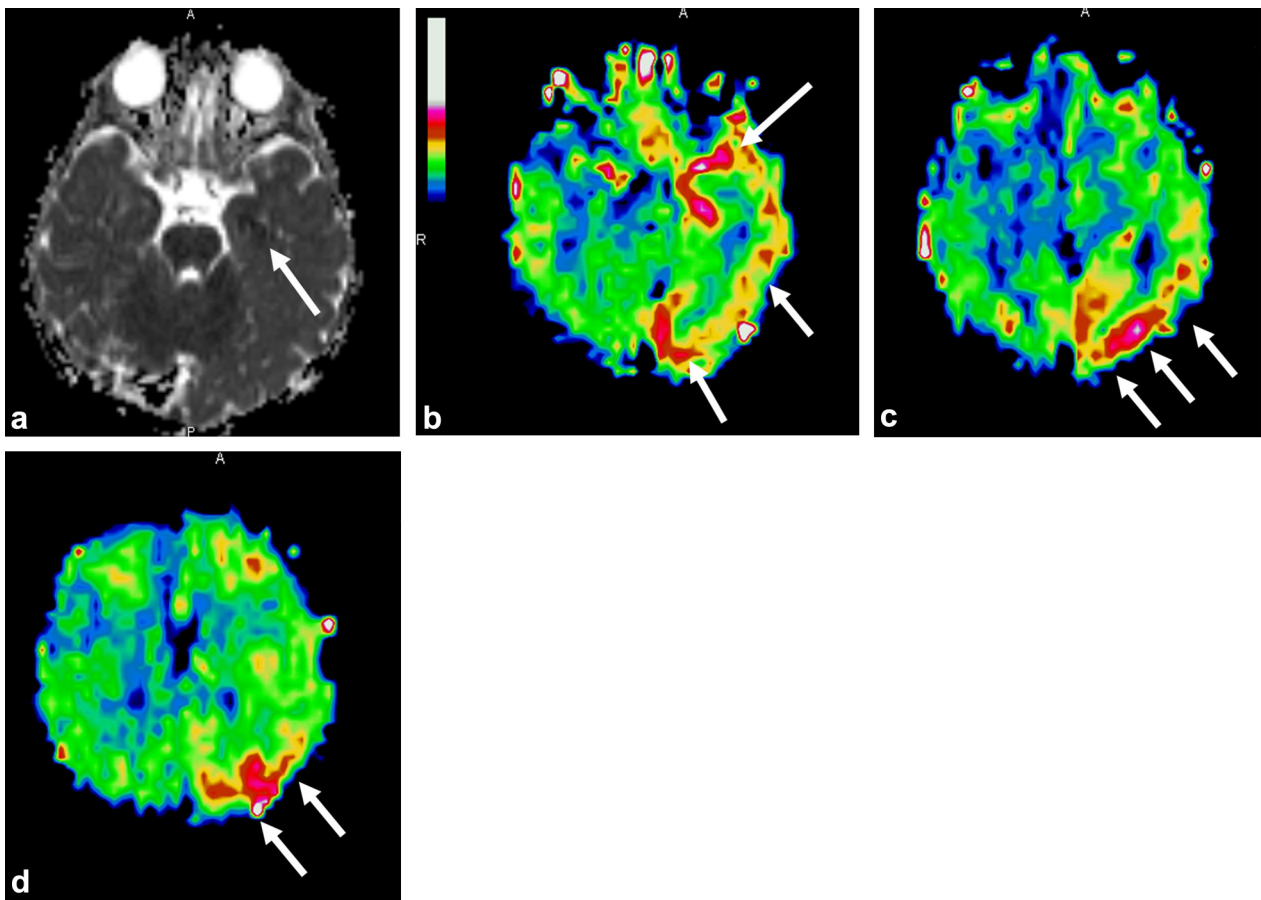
11-year-old boy with recent surgical right internal carotid occlusion. MR angiogram shows right internal carotid occlusion (a). DWI shows no evidence of ischemia. ASL maps (b–d) show the transit time effect with pseudohyperperfusion of the right hemisphere (arrowheads) as well as linear high signal intensity representing slow flow in cortical vessels (arrows).
